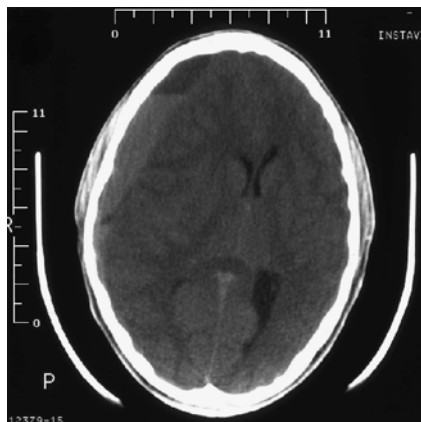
Axial CT. Subacute, partially hyperdense subdural haematoma with blood-serum sedimentation level along the right cerebral hemisphere. A resulting moderate midline shift in combination with a compression of the right ventricle is seen
